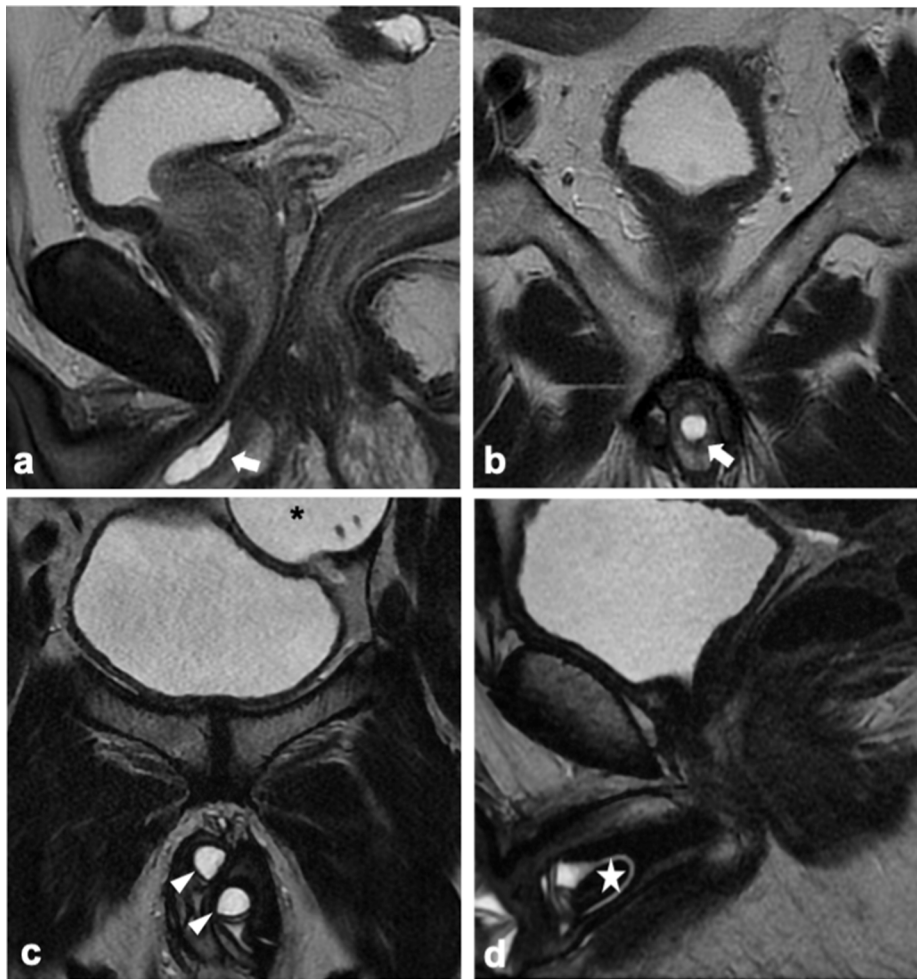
Sagittal (a) and coronal (b) T2w images show a hyperintense midline unilocular cystic lesion at the penile base close to the proximal bulbous urethra, in keeping with Cowper's gland syringocele. Coronal (c) and sagittal (d) T2w images show paired T2-hyperintense cylinders in the corpora cavernosa (arrowheads), a left-side pelvic fluid-filled reservoir (asterisk) and a hypointense rear tip extender (star) of a well-placed three-piece IPP. T2w T2-weighted, IPP Inflatable penile prosthesis.
